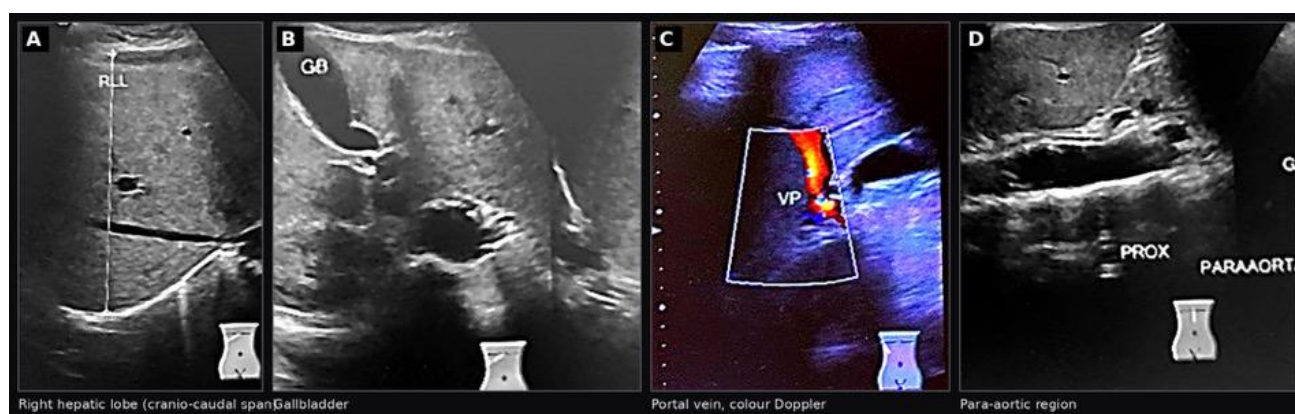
Abdominal ultrasonography performed on 18 September 2020 during the survey for extracranial large-vessel involvement. (A) Right hepatic lobe with the recorded calliper trace; the two recorded measurements were 14.25 cm and 11.18 cm. (B) Gallbladder and adjacent liver, with a 0.35 cm calliper measurement recorded on the study. (C) Portal vein interrogated with colour Doppler, showing unobstructed hepatopetal flow. (D) Para-aortic region, labelled by the operator as proximal and distal, in which no lymphadenopathy or focal abnormality was identified. Ultrasonography of this kind surveys the para-aortic soft tissues but does not measure aortic wall thickness and cannot exclude aortic or renal arterial involvement.
